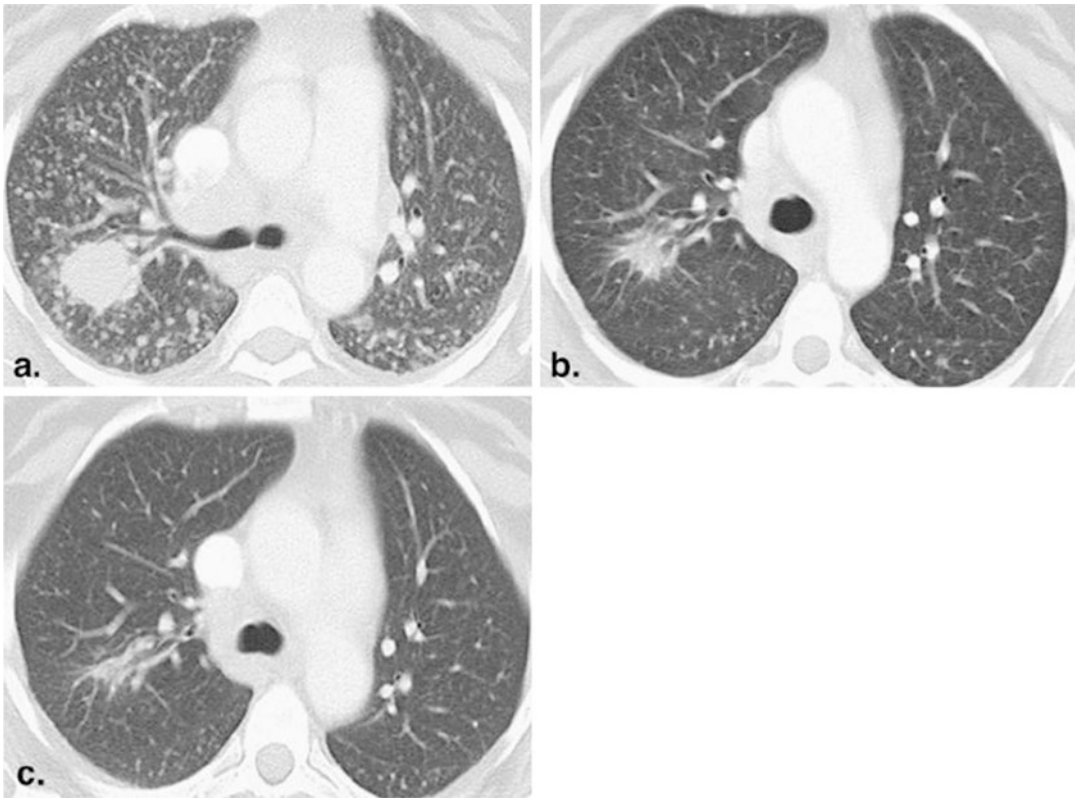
A 52-year-old female nonsmoker with lung adenocarcinoma treated with erlotinib. (a) Baseline computed tomographic scan prior to erlotinib therapy demonstrated a dominant mass in the right upper lobe with innumerable metastatic nodules. Epidermal growth factor receptor (EGFR) gene sequencing of the tumor showed EGFR mutation with exon 19 deletion. (b) After one cycle (2 months) of therapy, the mass was significantly
